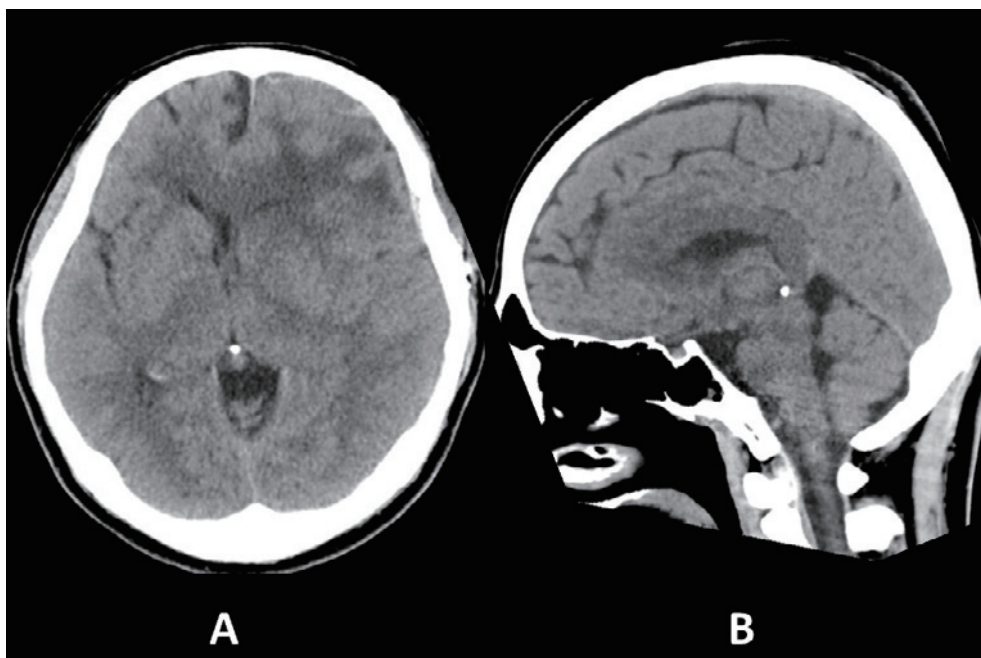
Brain CT performed 30 days after the autologous blood patch therapy showing the resolution of the brain shift and reappearance of the prepontine cistern. A, axial image; B, sagittal image.
